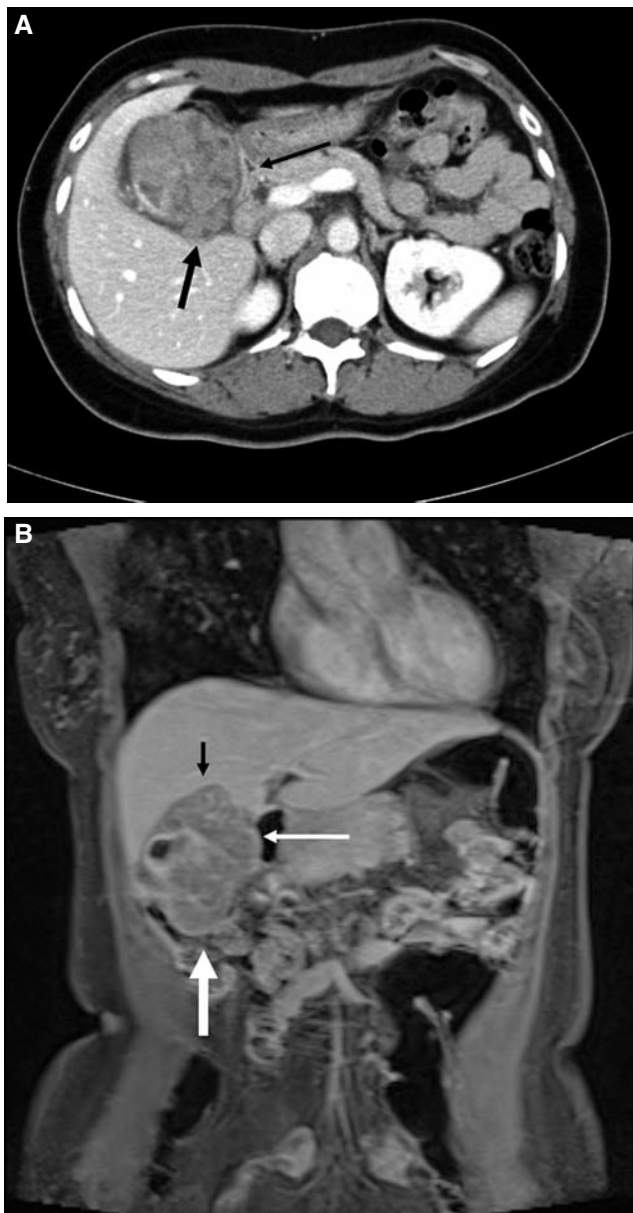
A) A large gallbladder mass has invaded the duodenum (thin arrow) and liver (thick arrow), as seen on the contrast-enhanced CT scan. B) The T1-weighted MR image shows a large gallbladder mass that has invaded the liver (black arrow), duodenum (thin white arrow) and colon (thick white arrow).
